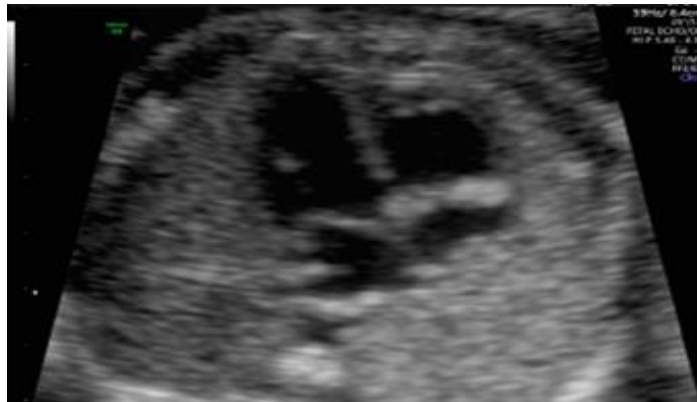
Diffuse calcifications of the left ventricle seen in the fetal echocardiography
